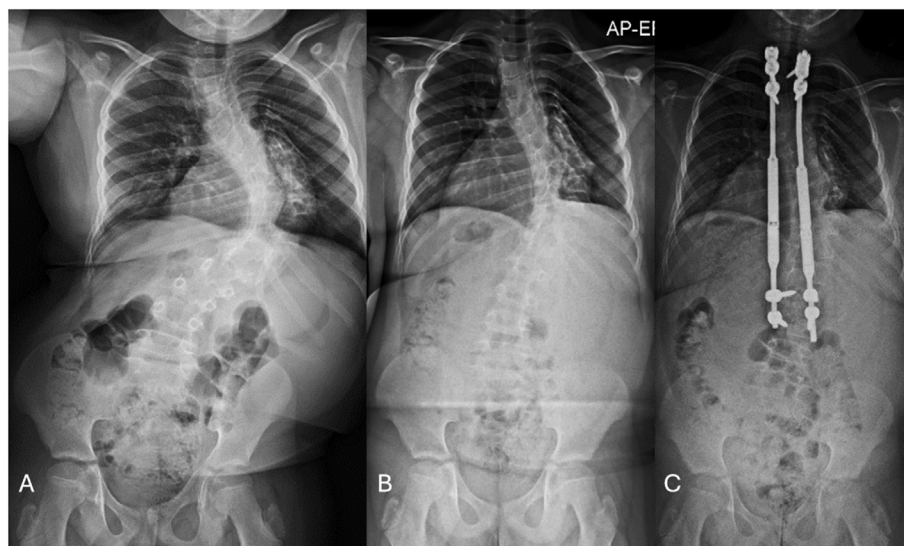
(A) Preoperative AP radiograph of an 11-year-old short-stature boy with idiopathic early onset scoliosis measuring 100°. (B) Reduction of scoliosis to 60° following 2 weeks of HGT at 50% body weight. (C) Final growing rod construct out of traction with correction to 35 degrees of scoliosis. HGT, halo-gravity traction.
